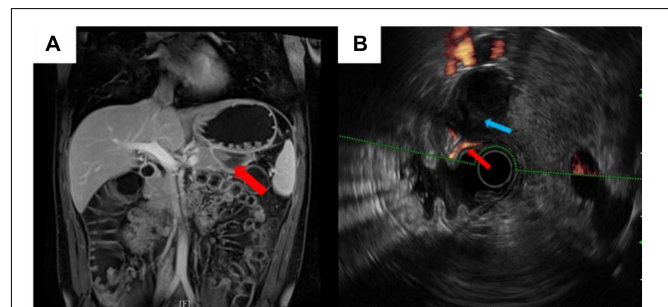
(A) Enhanced computed tomography (CT) of the abdomen. Red arrow showed a  $10 \times 5.2 \text{ cm}^2$  high-density shadow in the gastro-pancreatic gap. (B) Gastroscopy showed that the gastric mucosa was smooth and had no ulcer or bleeding spot in the upper digestive tract.
